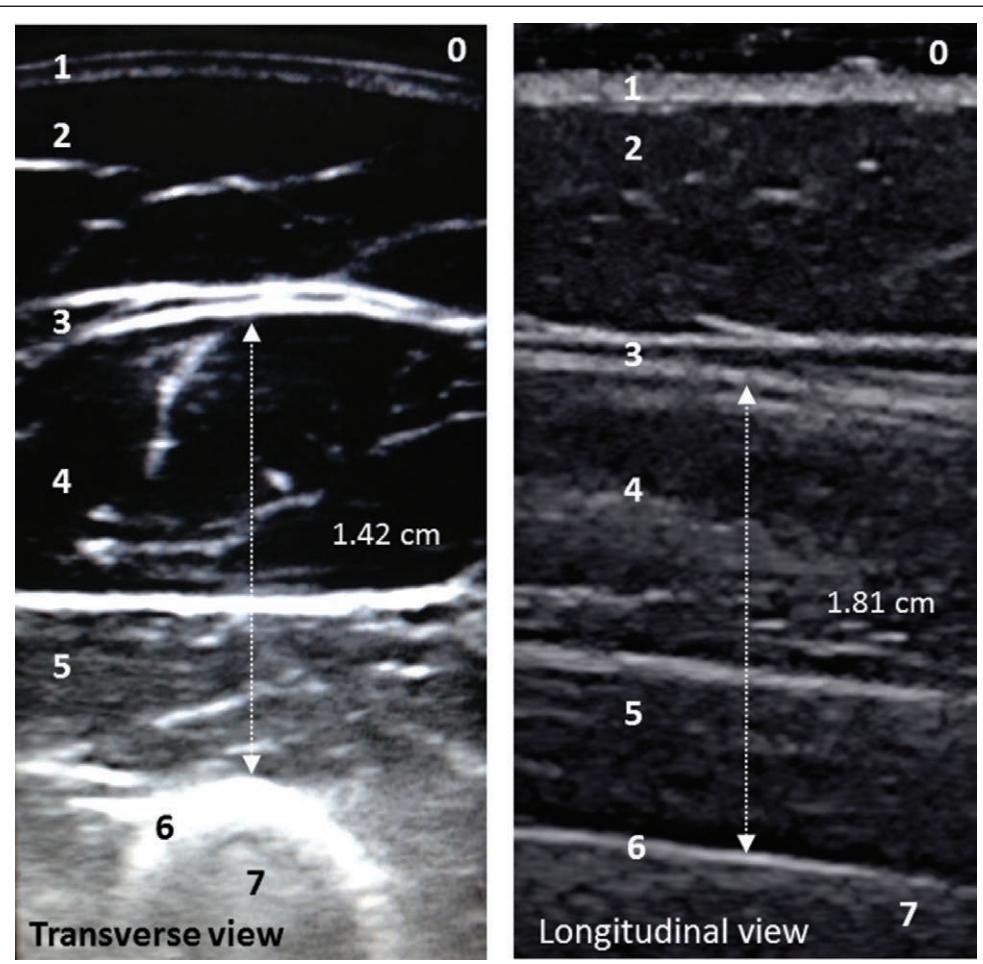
Thigh ultrasonography in transverse and longitudinal views in two different patients (0: layer of gel, no contact between the transducer and the skin is accepted, to confirm the absence of pressure of the transducer on the thigh; 1: skin; 2: fat; 3: quadriceps femoris fascia; 4: rectus femoris head of quadriceps femoris; 5: vastus intermedius head of quadriceps femoris; 6: outer cortex of the femur; 7: femur). On the transverse view, the femur is easily identified as a hyperechogenic semicircle, which has to be in the center of the image; quadriceps femoris thickness is measured vertically from the upper border of femur cortex to the under border of quadriceps femoris fascia. On the longitudinal view, the femur is identified as a roughly horizontal hyperechogenic row; the same measurement technique is followed, the center of the image corresponding to the center of the transducer that has to be located on the adequate marked skin location. The transducer has to be strictly perpendicular to the skin.
